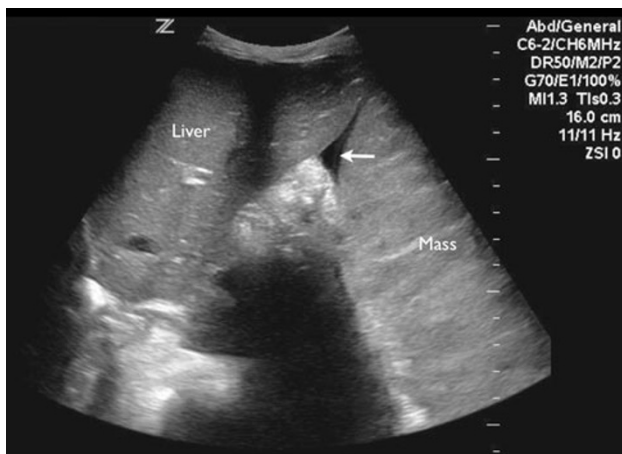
Two-dimensional B-mode ultrasound. Sagittal view of the right upper quadrant of the abdomen showing the liver, large abdominal mass and ascites (arrow)
